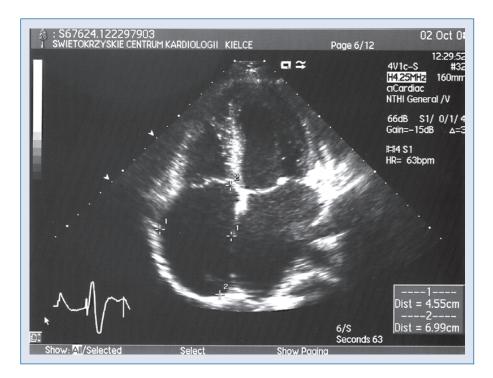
Echocardiography examination: apical four chamber view, atrial enlargement.
